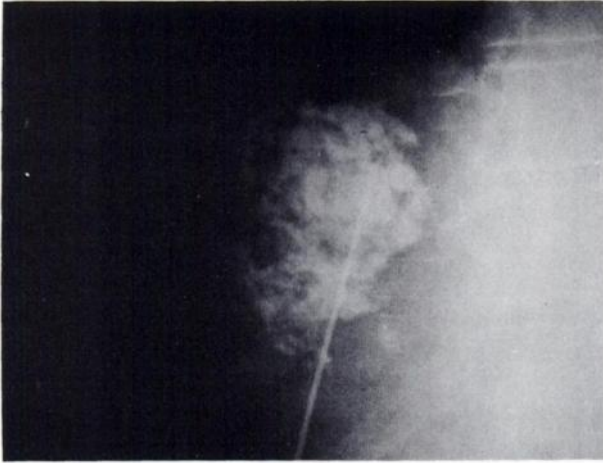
Roentgenographic visualization of abscess cavity after injection with radiographic contrast at open surgical drainage.
